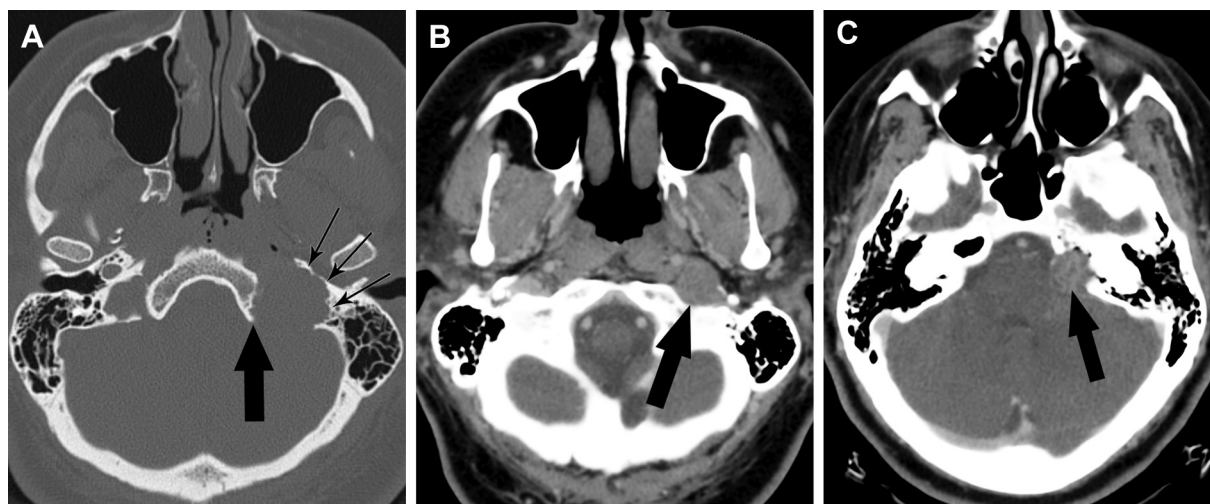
Enhanced-CT examination showing a mildly enhancing mass in the L-JF with (A) scalloped expansion of the JF (small arrows) with medial extension (large arrow) on bone windows; (B) extracranial extension in the carotid space; and (C) intracranial extension with involvement of the cerebellopontine angle (arrow).
